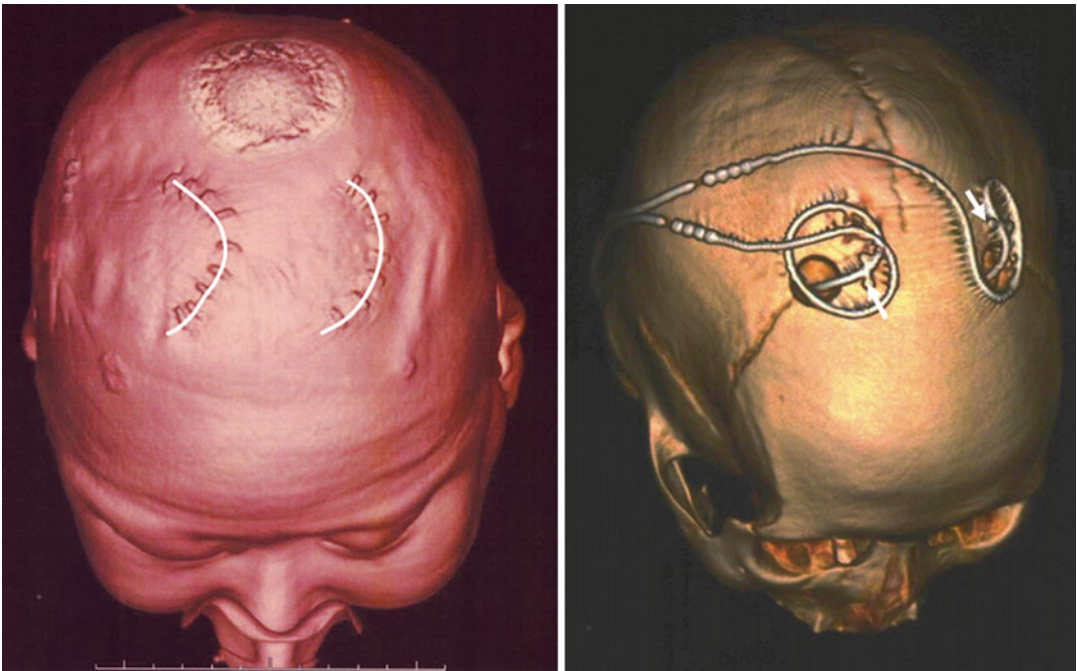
Postoperative 3D-computed tomography (CT) images showing the location of the skin incisions (*left, semicircular lines*) and burr holes (*right*). The deep brain
